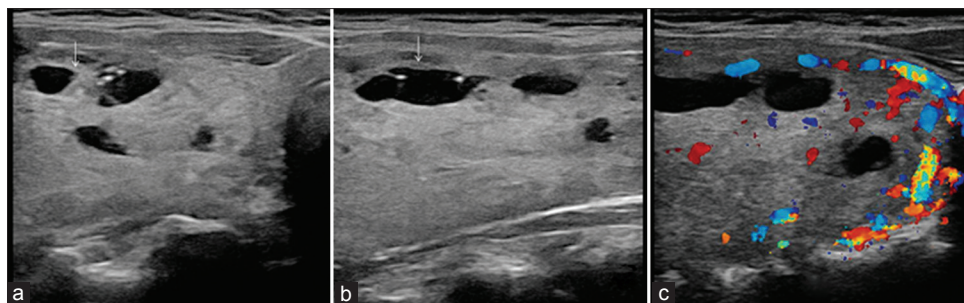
Malignant thyroid nodule. Hürthle cell (follicular) carcinoma in a 60-year-old woman. Transverse sonogram (a) of right lobe of the thyroid shows a partially cystic tumor with solid internal nodule (arrow) and thick walls. Color Doppler sonogram (b) depicts increased vascularity in solid parts of the tumor (arrow)
